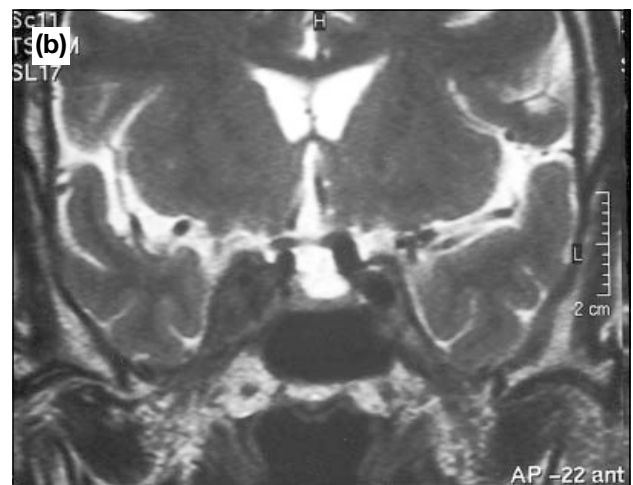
MRI of both orbits, 3 days after presentation. Coronal T1-weighted image (a) and coronal T2-weighted image (b) showing hypointense signal in the prominent right cavernous sinus; (c) post-gadolinium axial T1-weighted image showing the filling defect in the right cavernous sinus (arrow). Special note is made of the absence of parenchymal abnormality.
